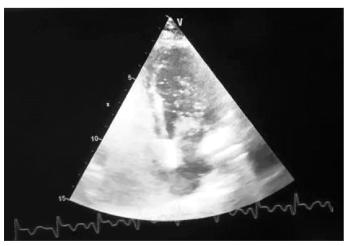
Agitated saline (bubble) contrast echocardiography-The appearance of bubble in left heart chambers immediately after the opacification of right heart chambers within 3 cardiac cycles suggest the presence right to left shunt at atrial level.
